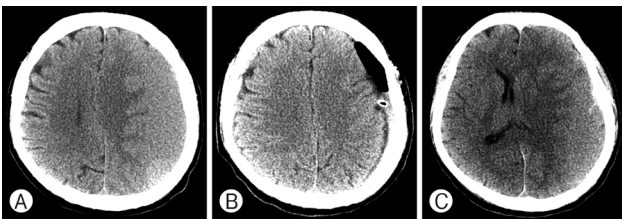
Computed tomography of a 66-year-old male with chronic subdural hematoma treated by burr hole trephination without saline irrigation. (A) Preoperative CT shows chronic subdural hematoma. (B) Immediate postoperative CT shows residual hematoma. (C) Postoperative CT 1 month after surgery shows recurrent CSDH with mass effect.
